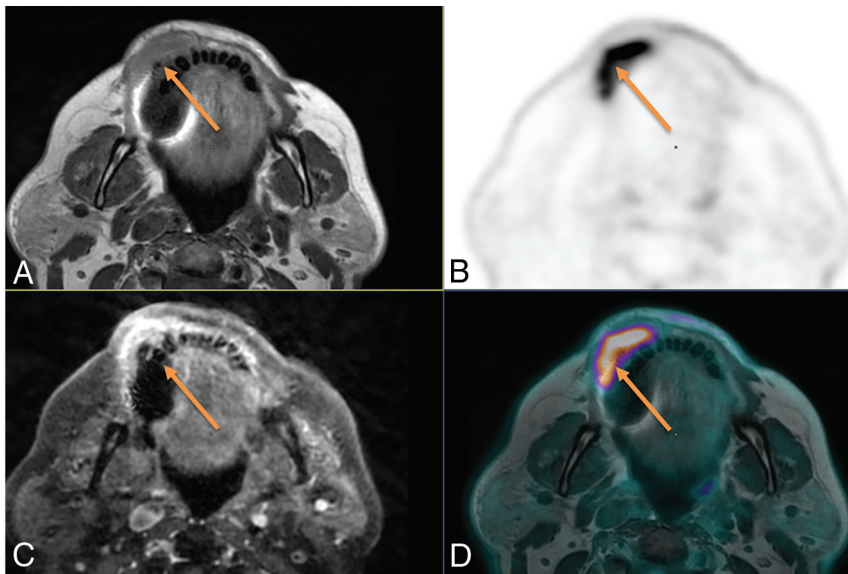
Local extension of a mandibular gingiva tumor in a 71-year-old woman. A, Axial contrast-free T1-weighted. B, Axial ^{18}F -FDG-PET image. C, 3D T1-weighted spin-echo (SE) contrast-enhanced sequence, axial plane. D, Fusion between axial T1-weighted and ^{18}F -FDG-PET. Both contrast-free and gadolinium-enhanced T1W MR imaging showed right vestibular invasion. Although bone invasion remained doubtful because of dental artifacts on MR alone, high FDG uptake includes a portion of the mandibular bone with margins that are clearly visible on the fusion images between PET and T1-weighted MRI, demonstrating bone involvement (arrow), which was pathologically confirmed.
